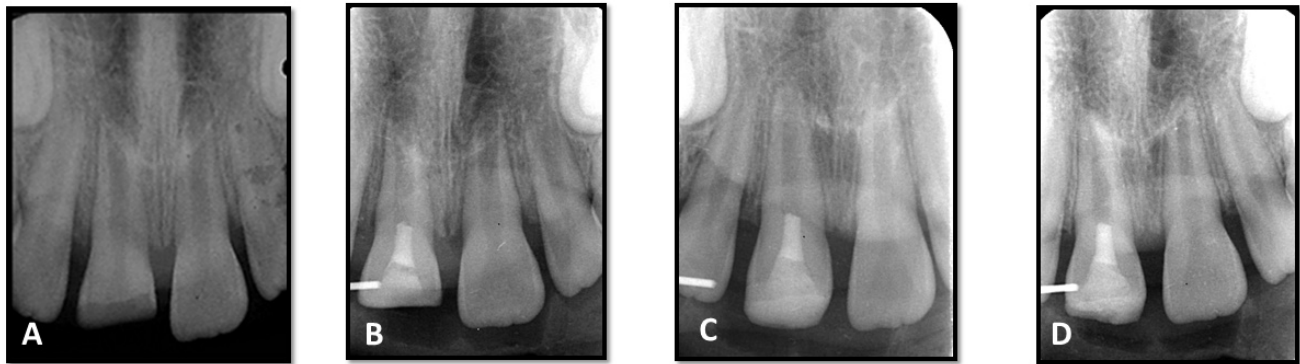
A) preoperative periapical radiograph; B) immediate postoperative radiograph after mineral trioxide aggregate coronal plug application; C) follow up radiograph at six months; and D) follow-up radiograph at 12 months.
